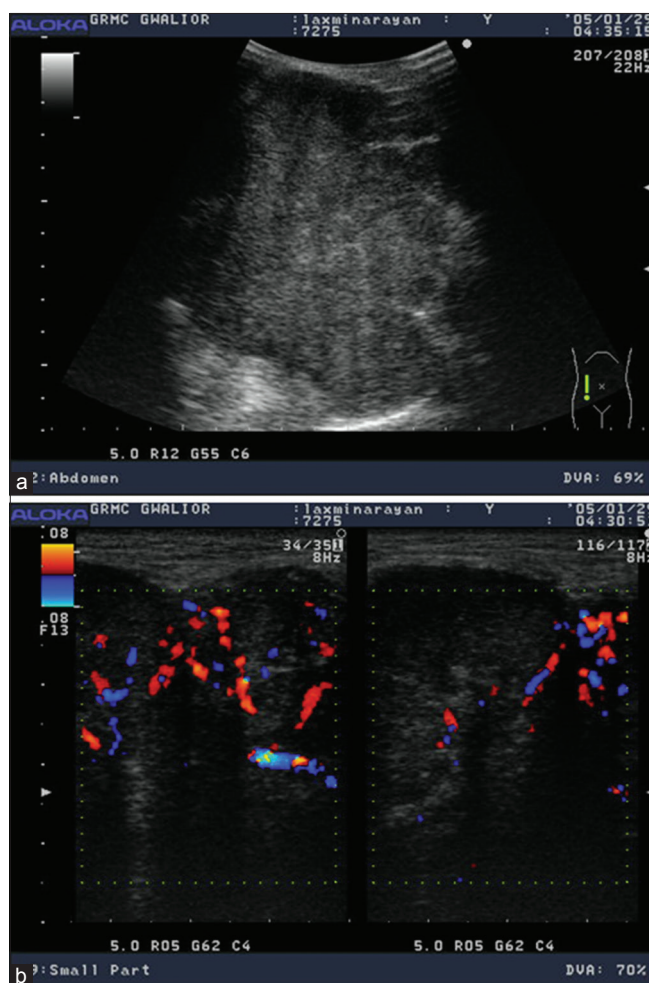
(a and b) Grayscale and color Doppler ultrasonography image of adenocarcinoma of right parotid gland
